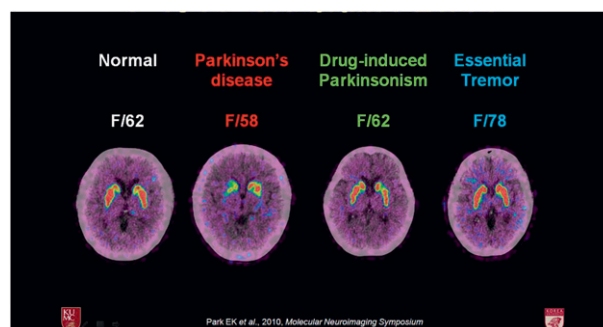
F-18 FP CIT Brain PET/CT comparing normal brain with Parkinson's disease, drug-induced parkinsonism and essential tremor.
